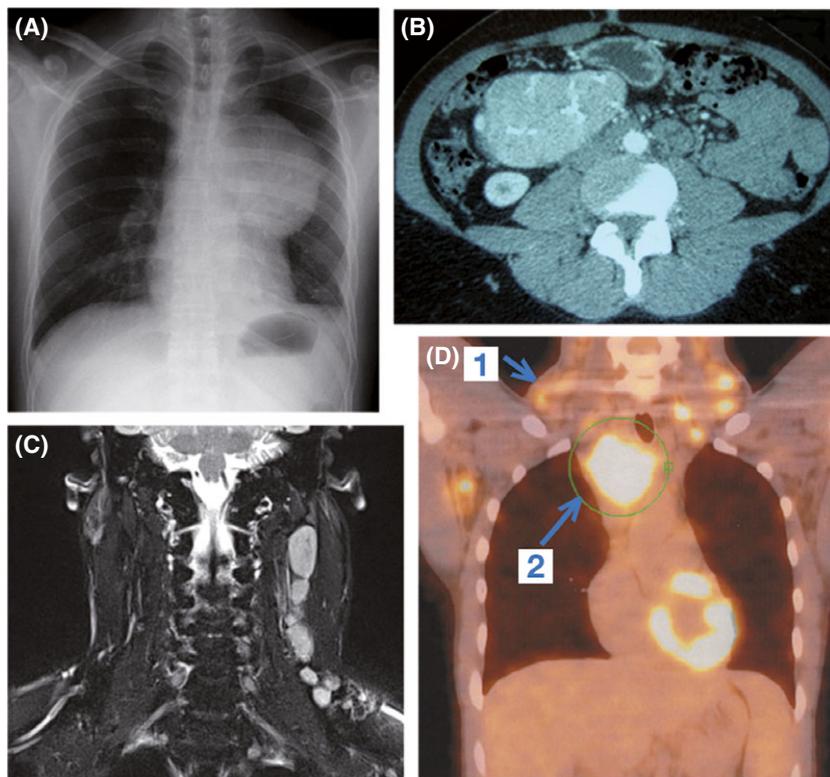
Imaging in Castleman disease. (A) Chest X-ray revealing an asymptomatic unique mediastinal mass; (B) Abdominal computed tomography (CT) scan showing a unique hypervascular mesenteric mass with an intense homogeneous enhancement following contrast; (C) Cervical magnetic resonance imaging (MRI) revealing several pathological lymph nodes in a single station, compatible with a diagnosis of unicentric Castleman disease; (D) Positron emission tomography/CT revealing a large tumoural mass of the upper mediastinum associated with multiple cervical and axillary lymphadenopathy; the first biopsy (i) performed on a cervical lymph node with moderate avidity [maximum standardized uptake value (SUV_{max}): 5-8] showed Castleman disease features while a second biopsy; (ii) performed on the mediastinal mass with a higher avidity (SUV_{max}: 11) was diagnostic for Hodgkin lymphoma.
